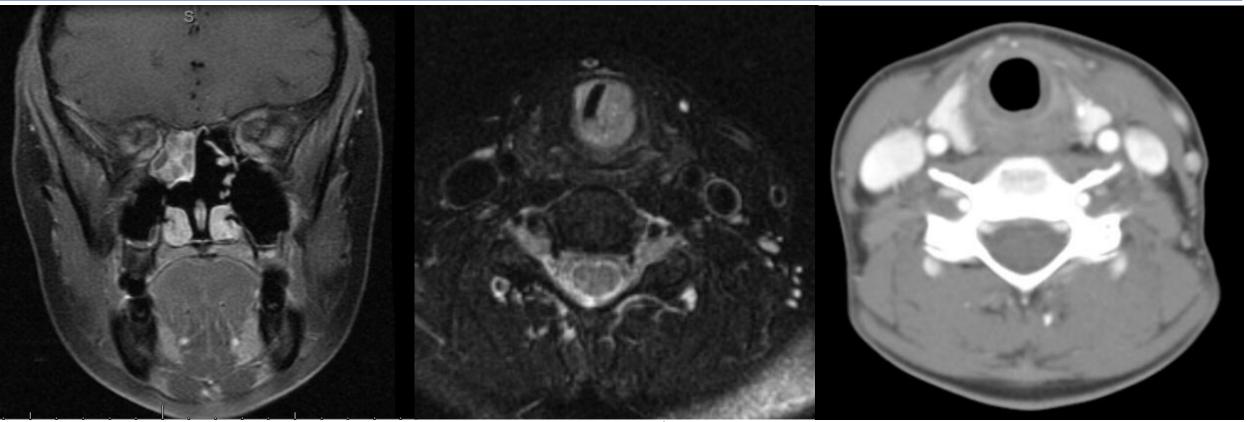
An MRI Face demonstrated a 4 cm right nasal cavity mass extending from the cribriform plate to the middle turbinate
